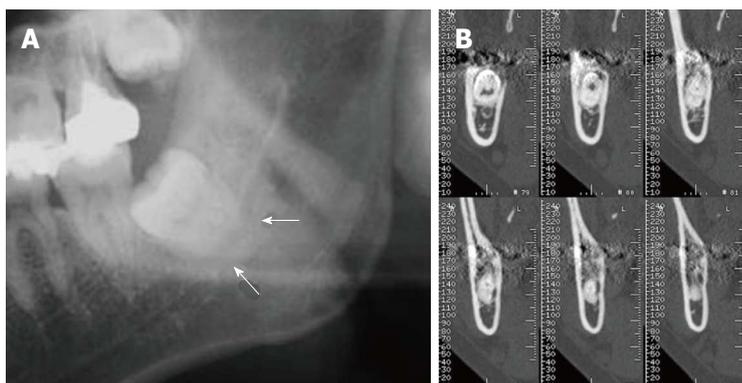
Root darkening and inferior alveolar canal shape. A: Darkening of the root is observed in this orthopantomography image. A black band is visible (white arrows) at the root apex site; B: A cross-sectional multi-detector computed tomography image indicates alterations (dumbbell shape) to the inferior alveolar canal shape and a loss of the lingual cortex of the mandibular bone.
